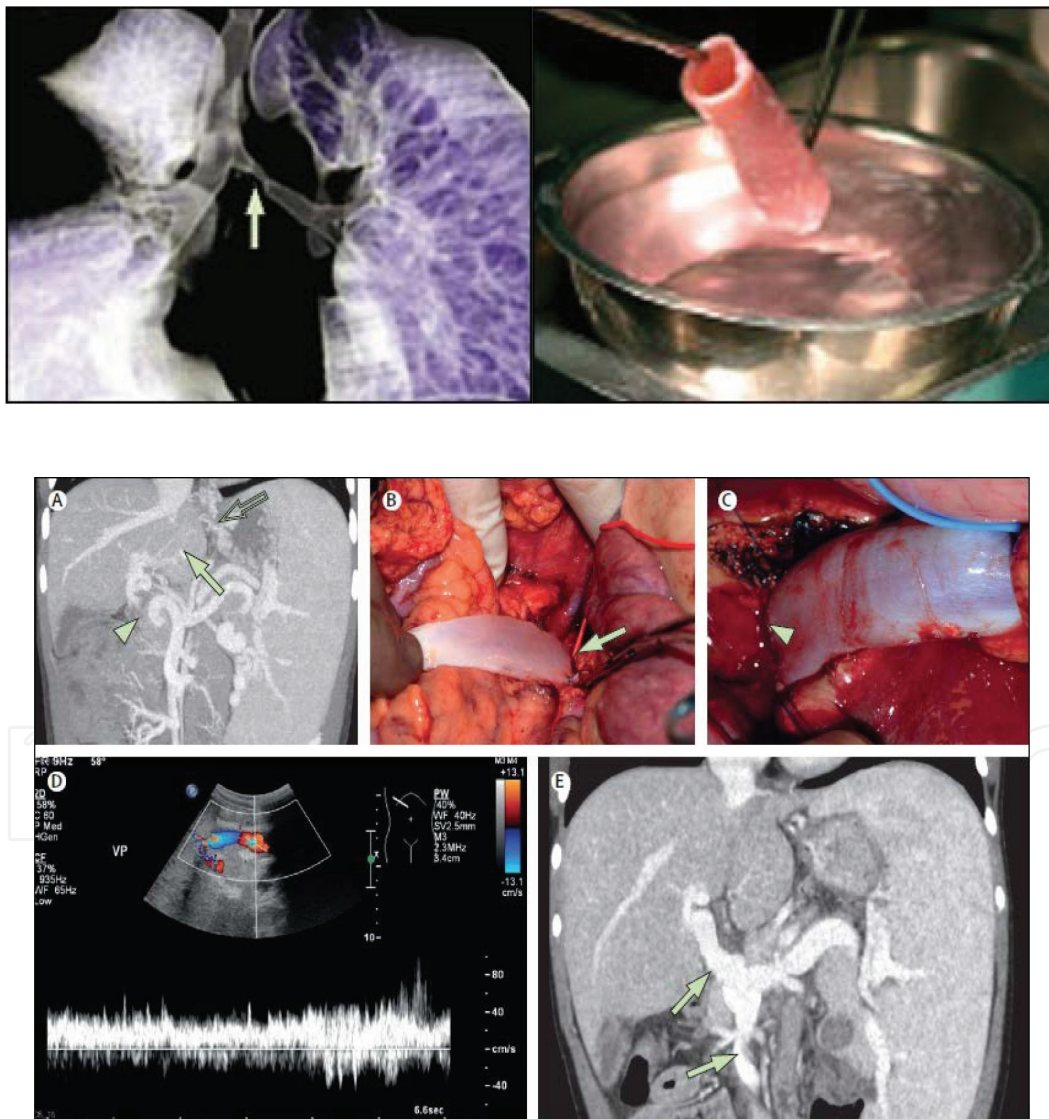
(A) Diagnostic CT angiography of intrahepatic portal flow (arrow), collaterals feeding the portal vein but no external portal vein in continuity (arrowhead) and enlarged spleen and collaterals around the oesophagus and in the liver hilum (open arrow). (B and C) Surgical correction showing graft attachment to the superior-mesenteric vein (arrow) and left portal vein (arrowhead). (D) Perioperative ultrasound with blood flows of 25–40 cm/s in the graft and intrahepatic portal vein. (E) Angiography showing a patent graft (arrows) 1 week after the surgery (reconstruction of 3–4 CT scans).
